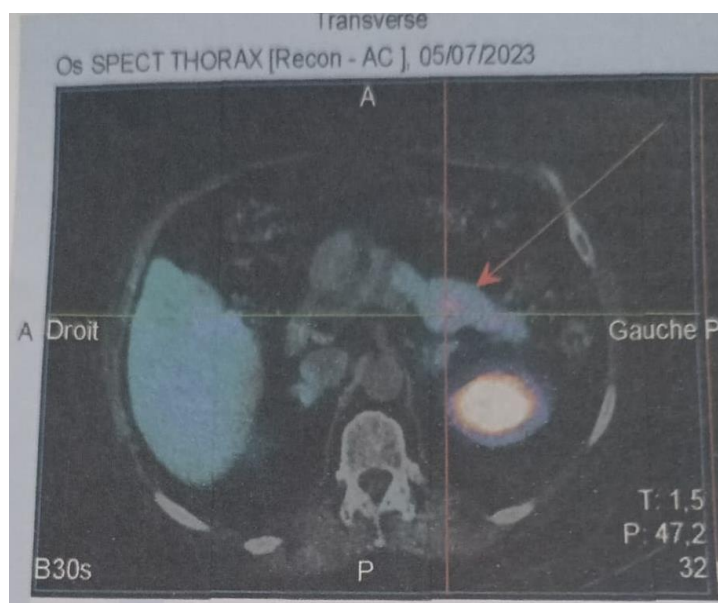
Hybrid SPECT/CT imaging demonstrating an intensely avid focus located in the pancreatic body, measuring 29.5 × 24.8 × 21.5 mm
